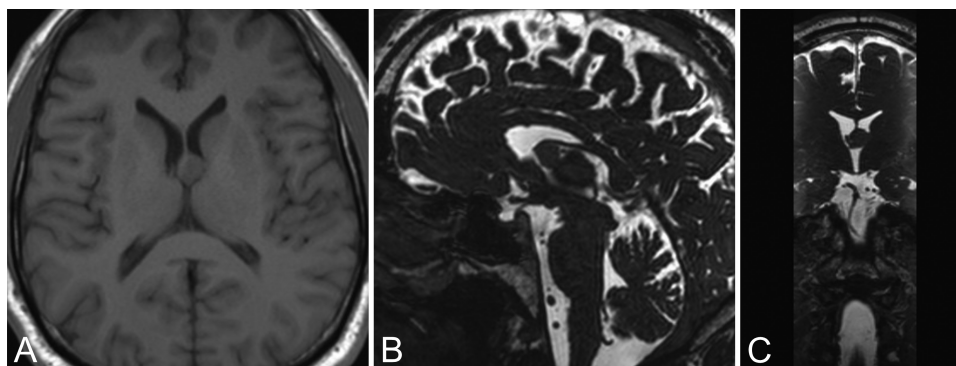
First follow-up MR images obtained 1 year after initial imaging, demonstrating no changes in the cyst's configuration in all 3 planes (A–C). Over the next 3 years, despite persistent symptoms of recurring headaches and visual impairment unrelated to the cyst, subsequent MR imaging showed no progression; thus, no surgical intervention was indicated.
